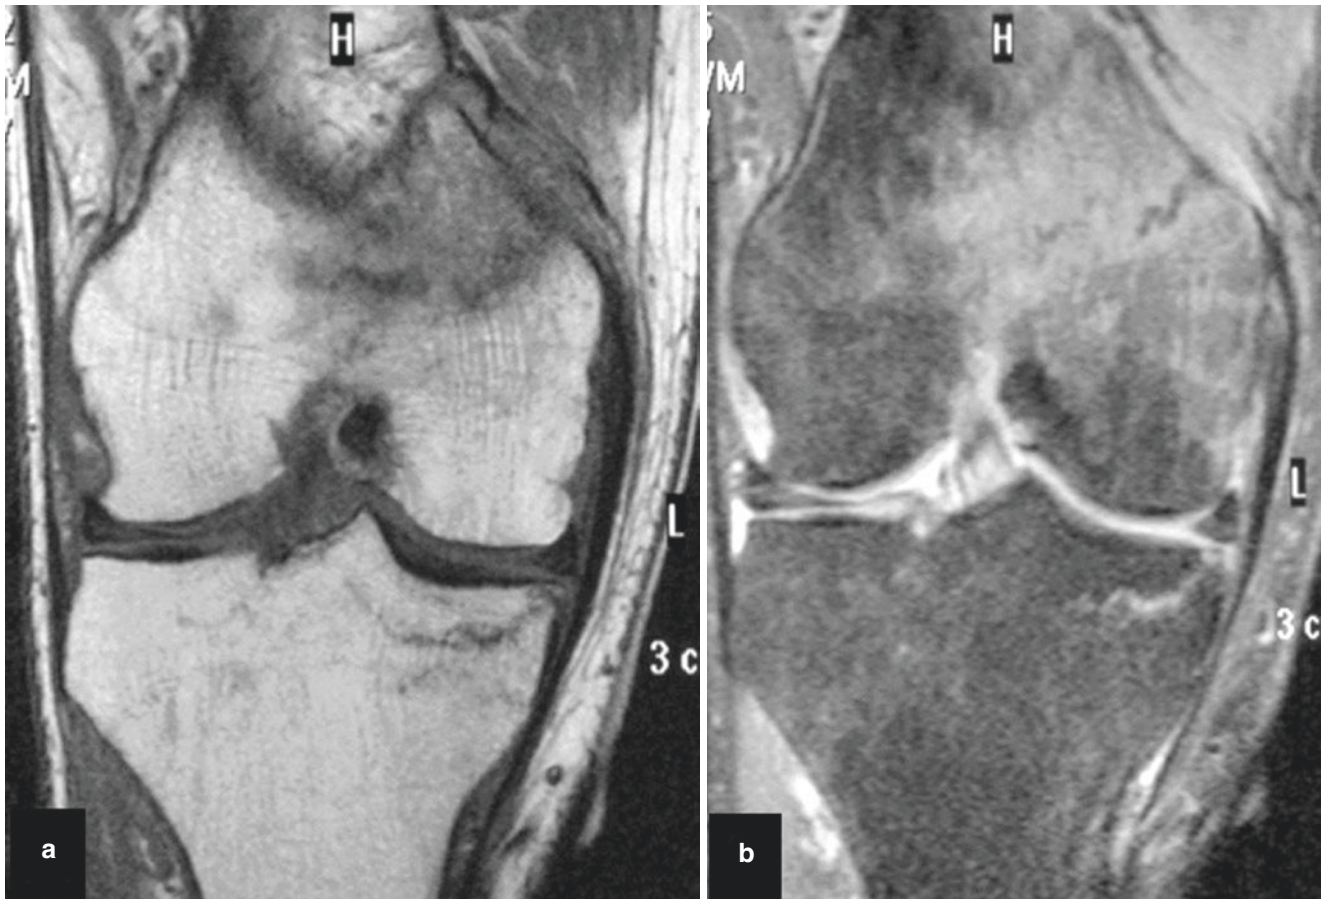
Osteomalacia. Coronal (a) T1-weighted and (b) fat-suppressed proton density-weighted MR images of the left knee of a 70-year-old man with drug-induced osteomalacia. Multiple trabecular
